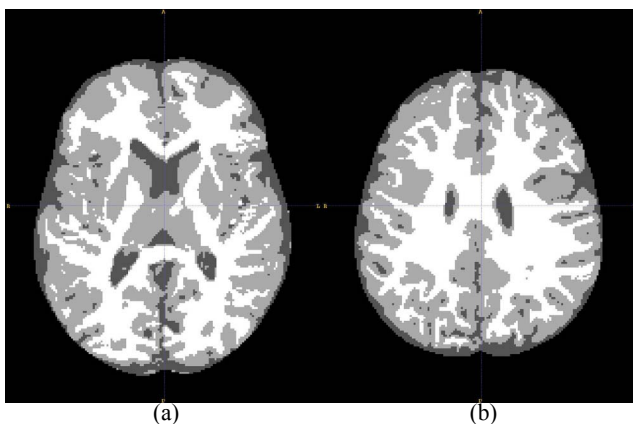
Axial slices showing the multivariate segmentation in the (a) subcortical and (b) cortical region. The segmentation method coupled/fused a nonparametric MRF model on the structural-MR image and a nonparametric model for orthogonal tensor invariants.
